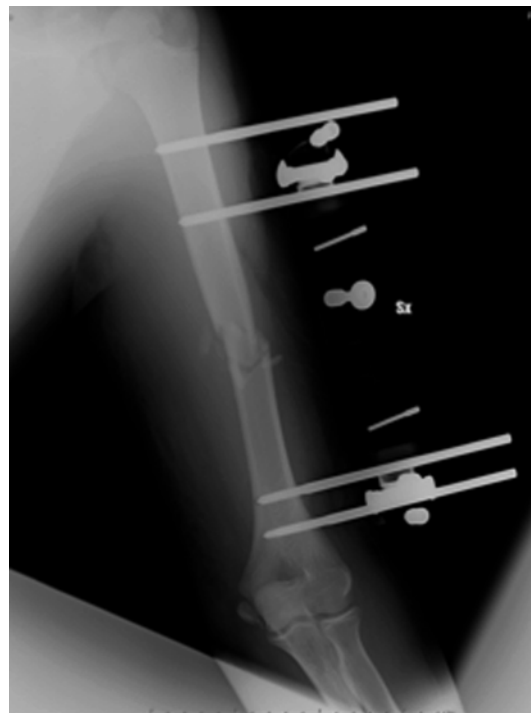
Reduced fracture appearance at X-ray control
